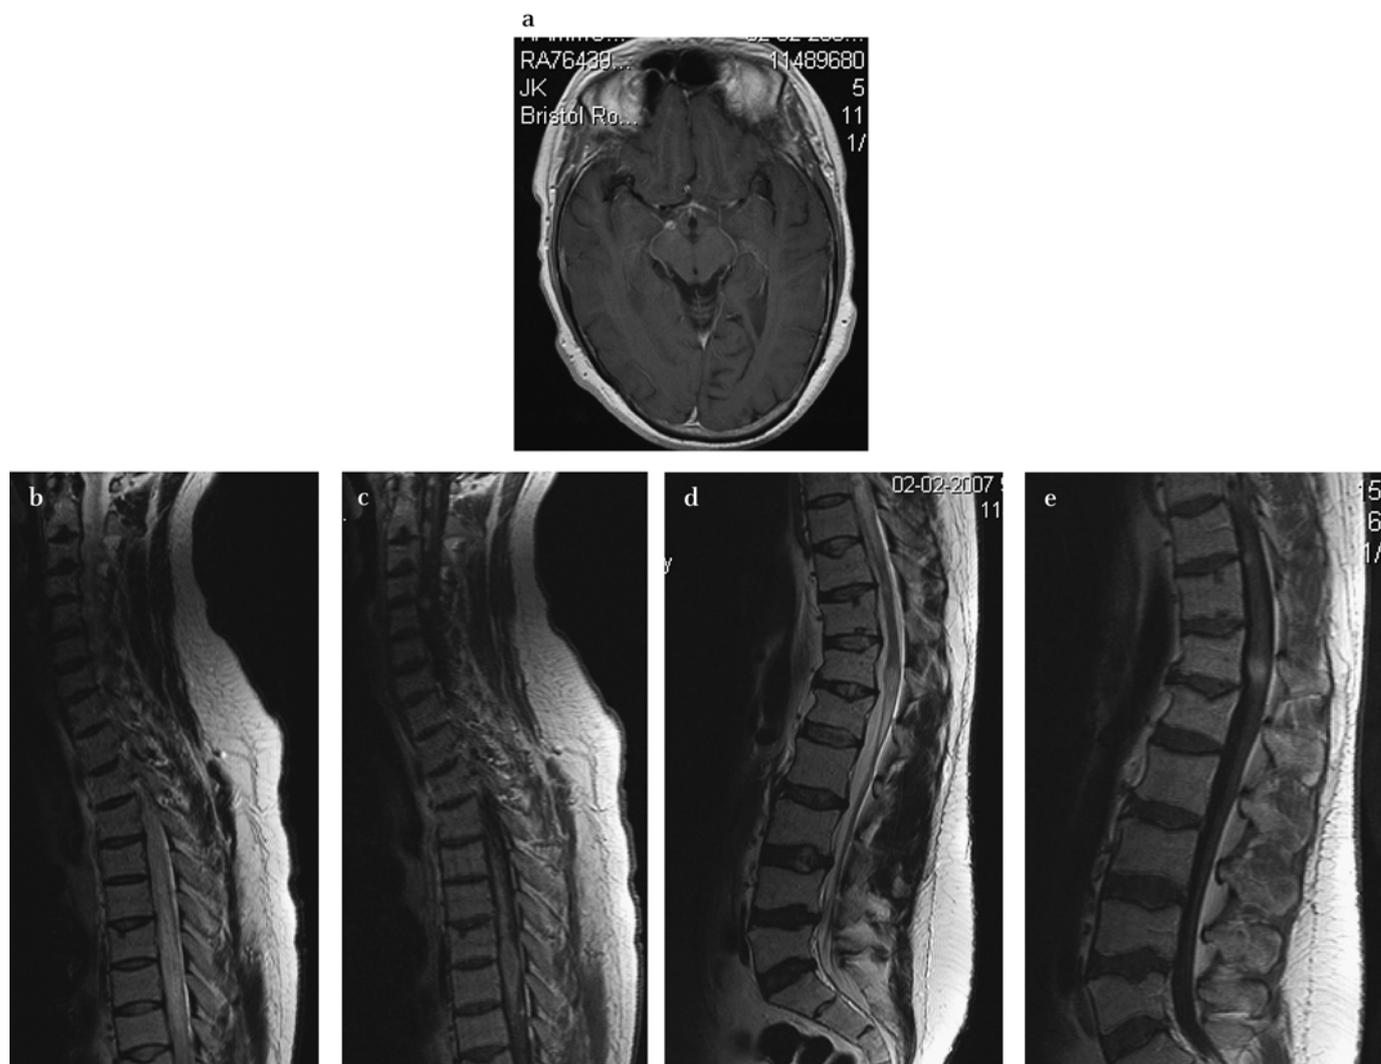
Cranial axial T1 weighted gadolinium enhanced MR image (A) demonstrates a basal meningitis with nodular enhancement of the optic chiasm and hypothalamus. T2 weighted sagittal MR images of the cervicothoracic (B) and thoracolumbar spine (D) demonstrate high T2 signal—that of oedema in the mid-thoracic cord. Gadolinium enhanced T1 weighted sagittal images of the cervicothoracic (C) and thoracolumbar spines (E) confirm an extensive spinal meningitic process with irregular thickening and nodular enhancement of the spinal leptomeninges in the cervical and thoracic regions and at the conus (E).
